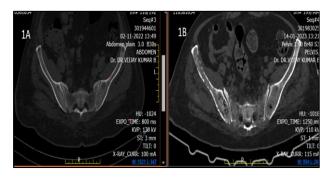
(A, B) MRI image showing gluteal collection.
